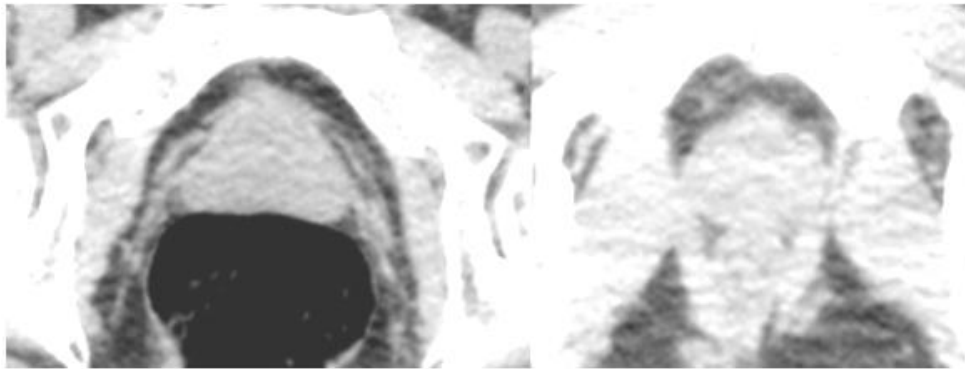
Normal CT prostate anatomy
